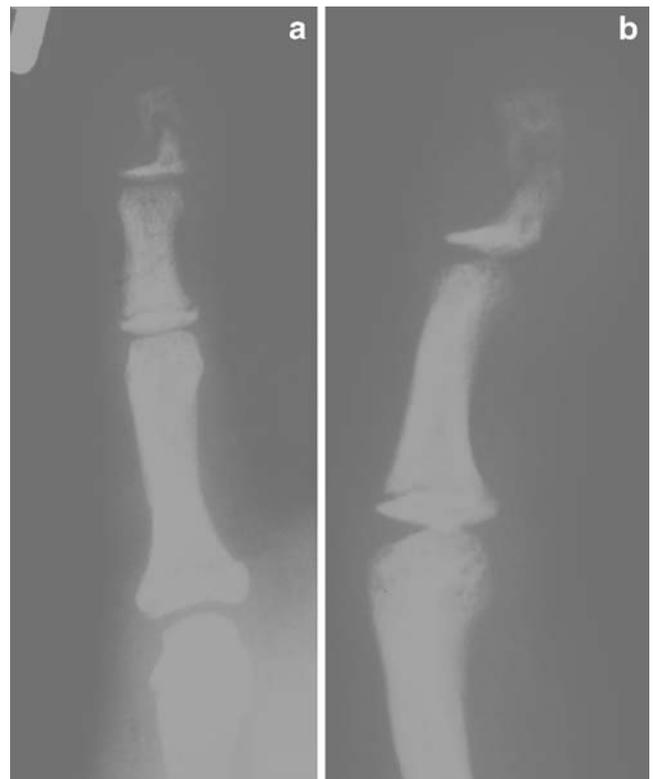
a Radiograph of fifth finger in Kirner's deformity (a. p. view). b Radiograph of fifth finger in Kirner's deformity (lateral view)
